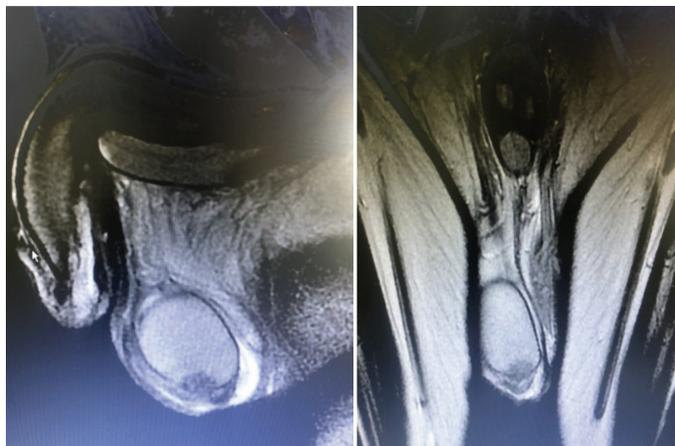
Scrotal magnetic resonance imaging of the tumor: Well-defined lesion located in the lower pole of the right testis
